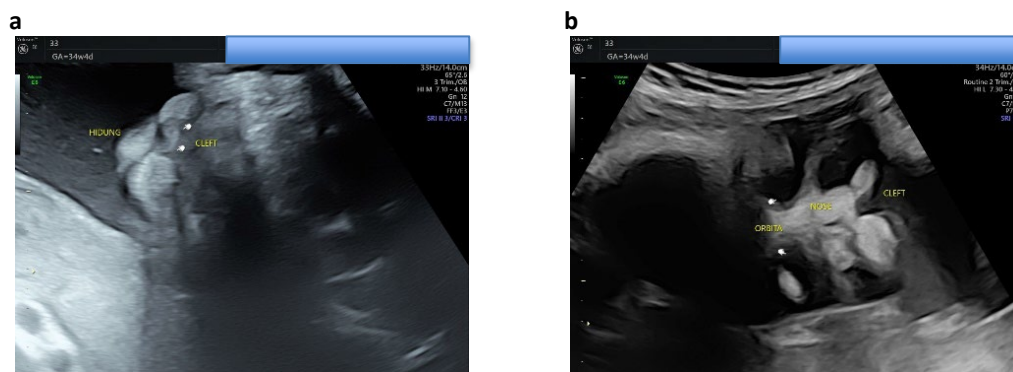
(a,b) Prenatal ultrasound at 30 weeks of gestation shows cleft lip and palate defect (between two white dots)
